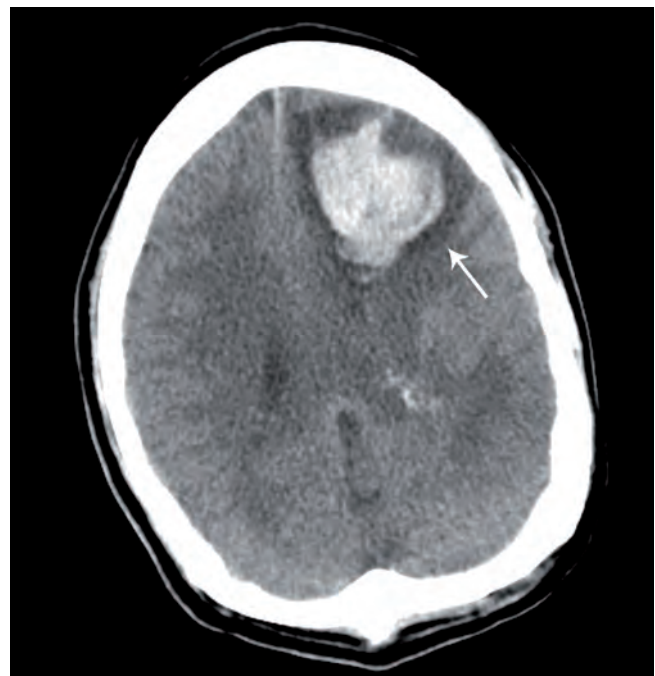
Computed tomography of the head revealed a large (4 cm maximum oblique transverse diameter) haematoma in the left frontal lobe with mass effect (arrow).
